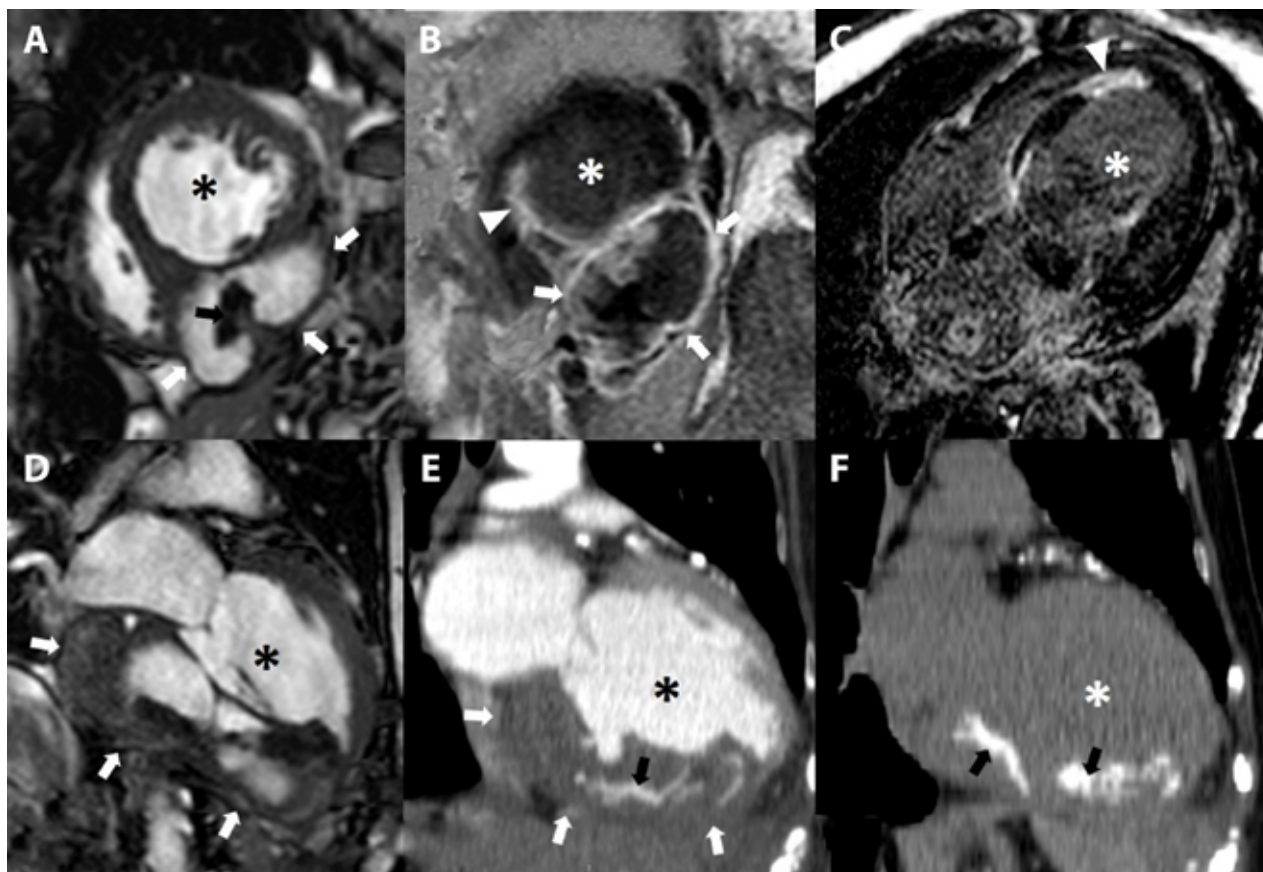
CMR (white arrows in a,b,d) and CT (white arrows in e) images showing large pseudoaneurysm from the infero-septal left ventricular wall extended from atria to ventricular apex in b-TFE sequences; post-contrast PSIR sequences demonstrated pericardium hyperintensity (white arrows in b) and transmural LGE in left myocardial septal wall (arrow head in b and c). Vertical long axis computed tomography (CT) view depicting linear hyperdensities consisting with surgical material of previous pseudoaneurysm treatment (black arrow in e and f).
